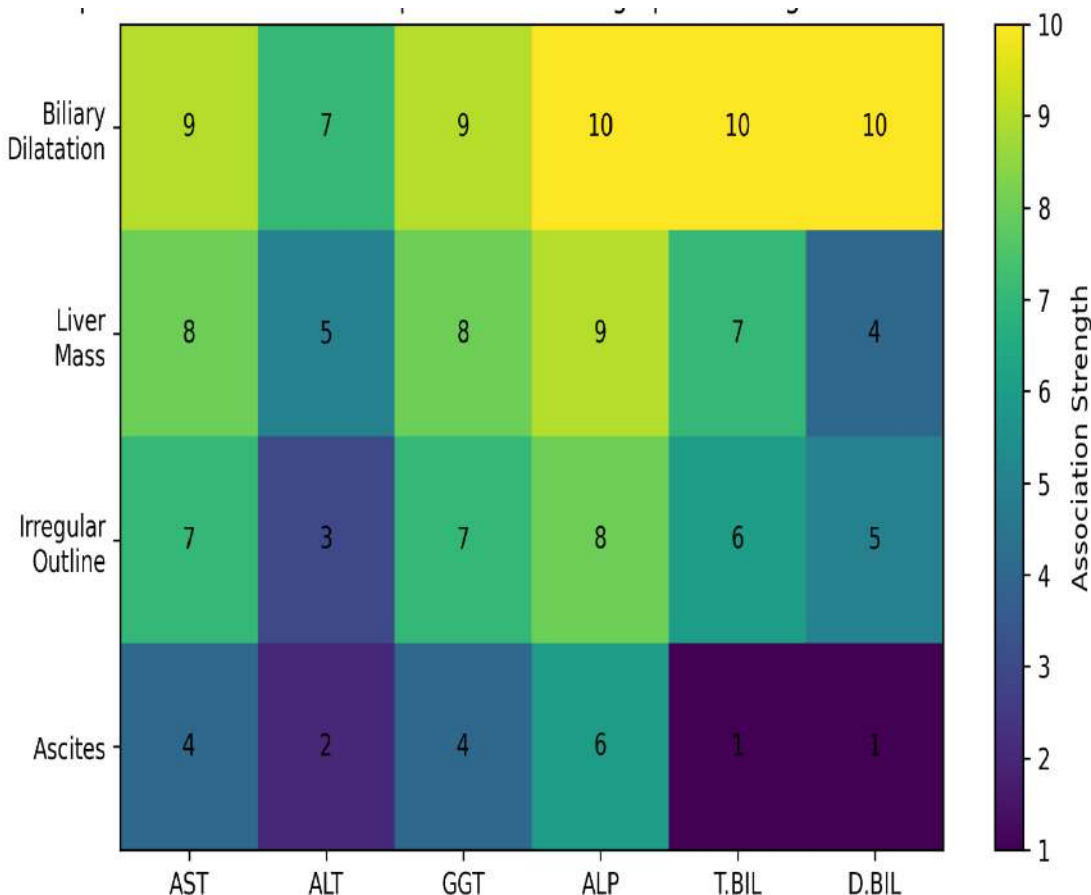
Heatmap Demonstrating Statistical Relationships Between Sonographic Findings and Liver Function Parameters
